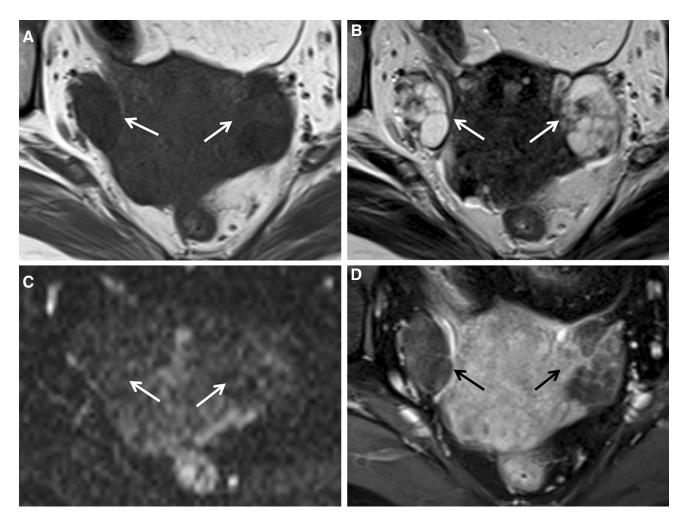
Axial magnetic resonance images. A T1-weighted image, B T2-weighted image, C Diffusion-weighted image, D Contrast-enhanced T1-weighted image with fat suppression Pelvic MRI shows bilateral ovarian masses (approximately 5 cm in diameter) with numerous loculi of different sizes, up to 20 mm in maximum dimension, and septal structure (*arrow*). The cystic
